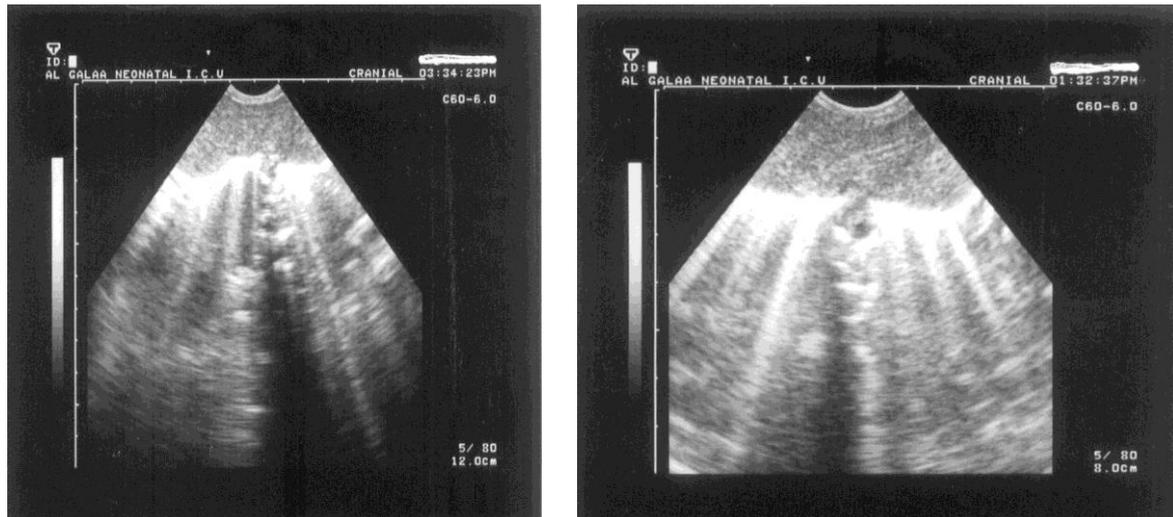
Case 22: A male preterm neonate, 33 weeks, with grade 1 RDS showing (a)reterophrenic striped pattern of hyper-echogenicity diverging radially, observed only on expiration., (b) the second ultrasound was after development of BPD showing hyper-echogenicity seen by ultrasound in cases of RDS only resolved partially on follow up evaluation appearing less homogenous and less extensive. The diaphragm is not clearly visualized and is replaced by hyper-echoic line with hyper-echoic reverberation artifact filling the area behind the diaphragm, with persistence of the hyper-echogenicity with interspersed normal areas in-between with irregular hyper-echogenicity in BPD.
